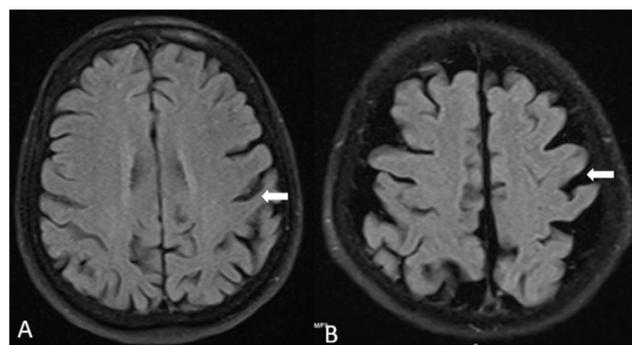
Axial FLAIR MR images at level of supraventricular showed A); global atrophy score grade 1: slight enlargement of the sulci (white arrow), B); global atrophy score grade 3: knife blade-shaped enlargement of the sulci (white arrow)
